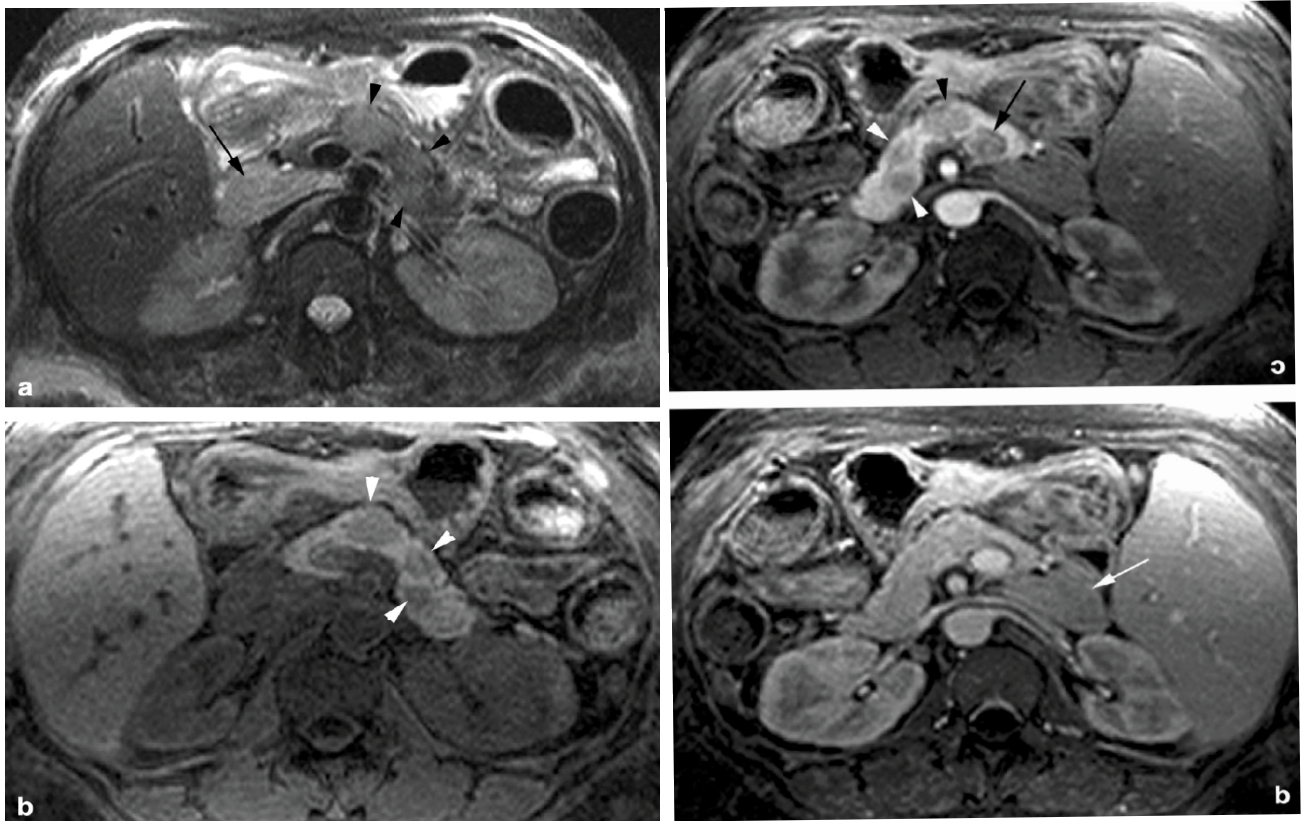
MRI finding in a patient with pancreatic sarcoidosis. (a). Axial T2-weighted showing three poorly defined masses in the pancreatic body and tail [arrowheads]. (b). Axial non-contrast-enhanced three-dimensional fat-saturated T1-weighted. The pancreatic masses within the pancreas are more conspicuous (arrowheads). (c). Axial three-dimensional fat-saturated T1-weighted that demonstrates decreased enhancement of the pancreatic masses [arrowheads]. (d). Axial three-dimensional fat-saturated T1-weighted the pancreatic masses are imperceptible because they have become isointense to the normal pancreatic parenchyma. Note the enlarged enhancing peripancreatic lymph node (arrow).
